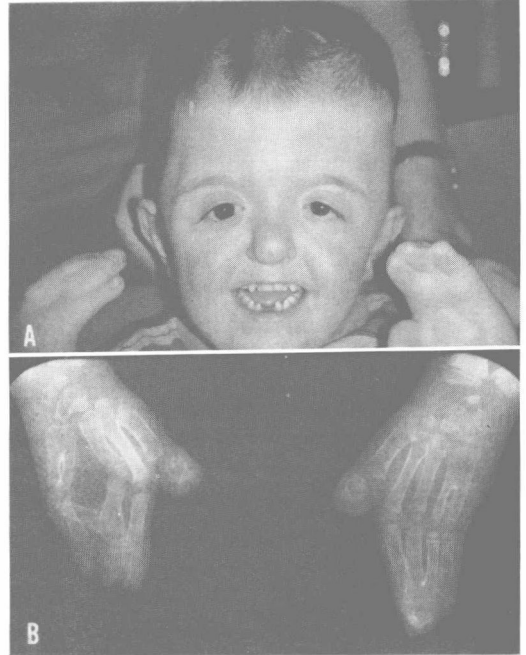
A, Apert's syndrome or acrocephalosyndactyly. Craniofacial changes shown include antimongoloid slant of eyes, low-set ears, bulbous nose and tooth loss. B, Radiograph of hands showing syndactyly.
